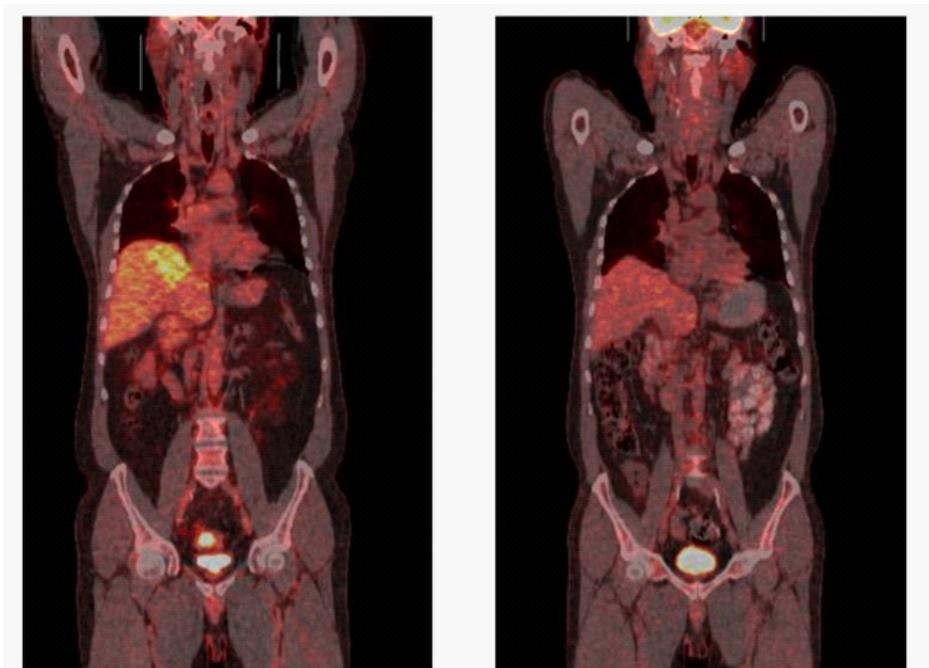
Pre and posttreatment fused F^{18} FDG PET/CT images of patients who received 1.8 GBq Y^{90} microspheres treatment for CRC liver metastases demonstrated complete metabolic response.
